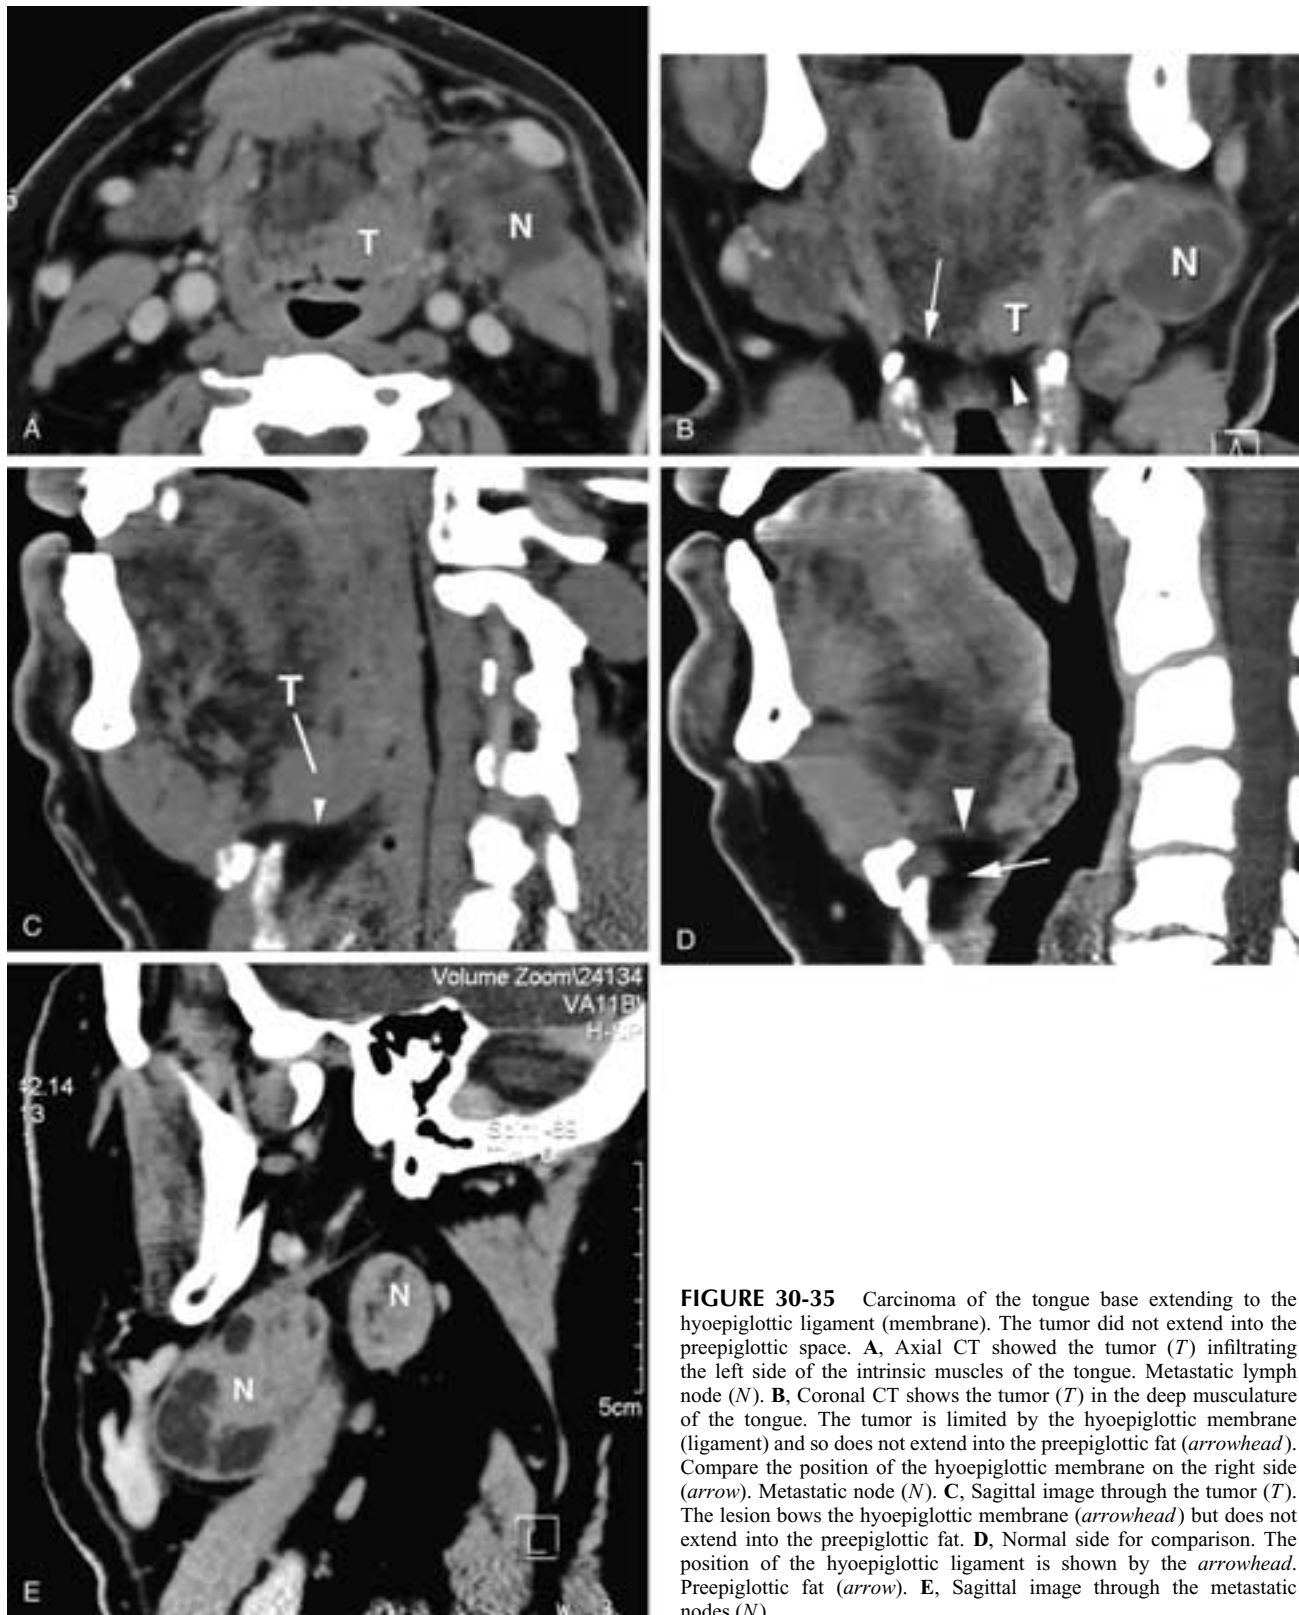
Carcinoma of the tongue base extending to the hyoepiglottic ligament (membrane). The tumor did not extend into the preepiglottic space. A, Axial CT showed the tumor (*T*) infiltrating the left side of the intrinsic muscles of the tongue. Metastatic lymph node (*N*). B, Coronal CT shows the tumor (*T*) in the deep musculature of the tongue. The tumor is limited by the hyoepiglottic membrane (ligament) and so does not extend into the preepiglottic fat (*arrowhead*). Compare the position of the hyoepiglottic membrane on the right side (*arrow*). Metastatic node (*N*). C, Sagittal image through the tumor (*T*). The lesion bows the hyoepiglottic membrane (*arrowhead*) but does not extend into the preepiglottic fat. D, Normal side for comparison. The position of the hyoepiglottic ligament is shown by the *arrowhead*. Preepiglottic fat (*arrow*). E, Sagittal image through the metastatic nodes (*N*).
